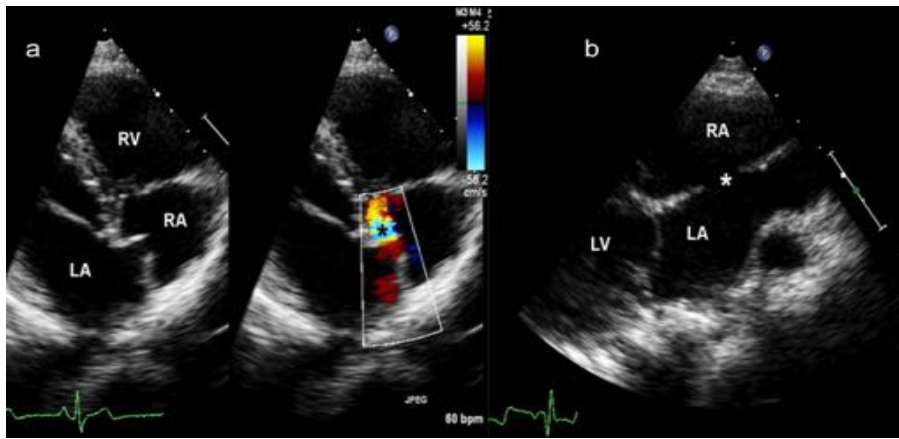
If subcostal imaging is of poor quality, a parasternal fore-shortened view (A) or a low or high right parasternal view (B) are two good options for ASD (*) visualization
